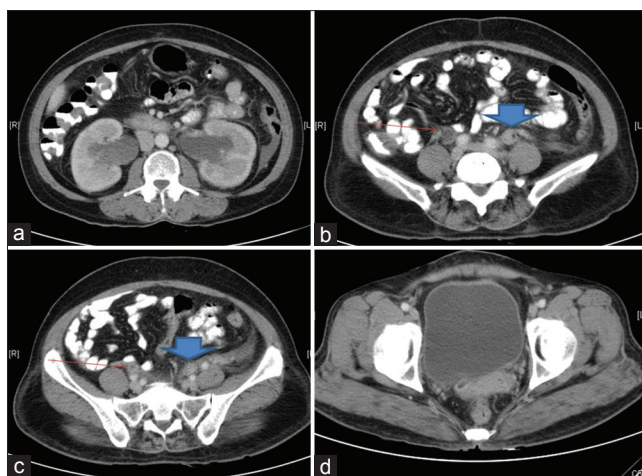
Venous phase of contrast-enhanced computed tomography of abdomen and pelvis showing: (a) bilateral global dilatation of calyces and pelvis, (b and c) red and blue arrows showing right and left ureters respectively, (d) showing normal urinary bladder
